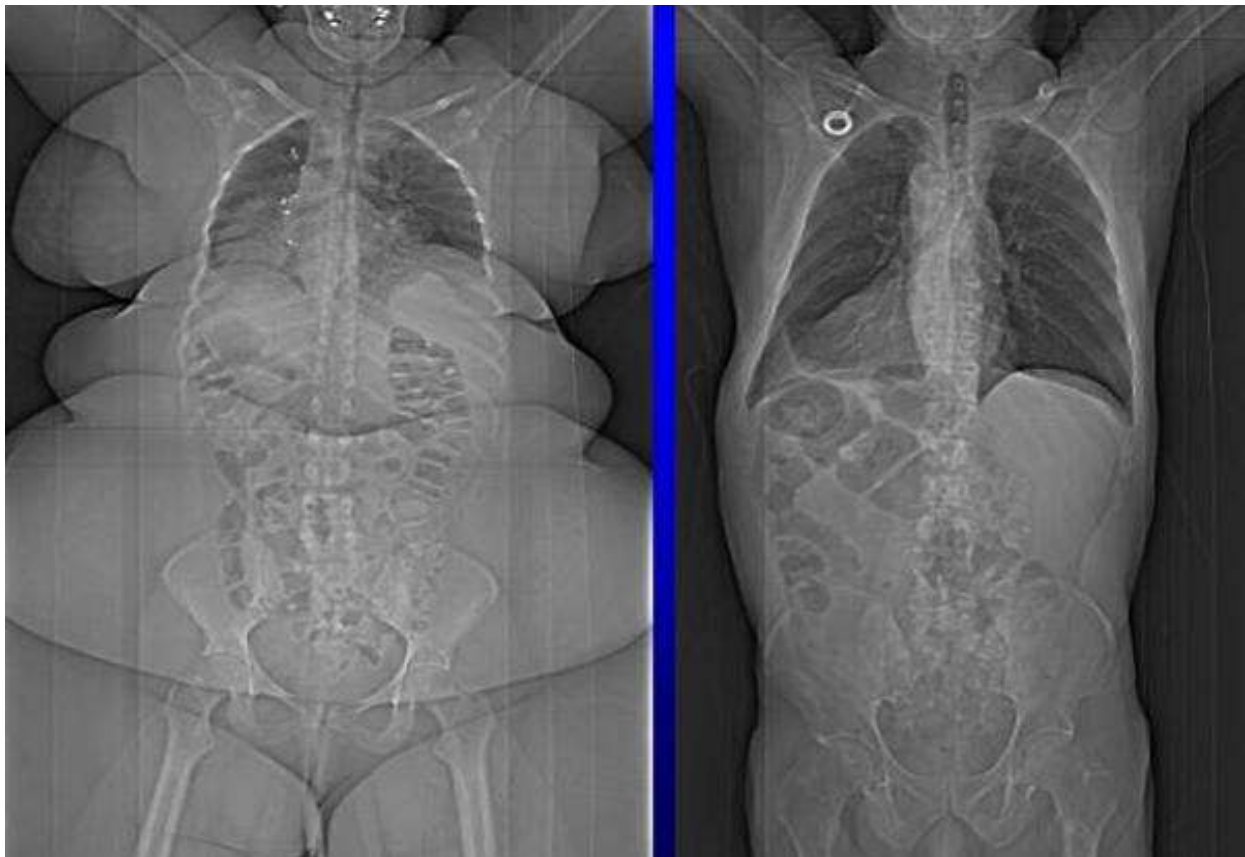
Shows the X-Ray of an obese person (Left) and a normal-weighted person (Right) comparison.
